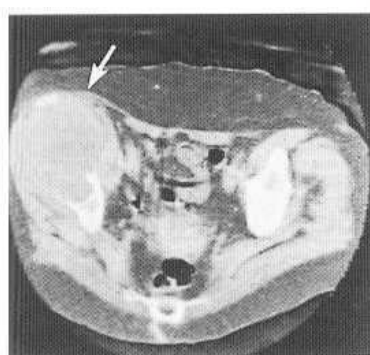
Metastasis from carcinoma of thyroid. (A) A localised view of the anterior inferior iliac crest shows a small radiolucent defect with a faint sclerotic margin (arrows). (B) Five years later a very large destructive bone lesion is present with relatively well defined margins and apparent strands of calcification within the lesion. (C) CT confirms the very extensive nature of the tumour and shows the soft-tissue planes to be preserved (arrow). The strands of calcification are shown to be residual bone anteriorly and posteriorly and not new bone in the metastasis. (D,E) Common iliac arteriography (subtraction images) demonstrates the very vascular nature of this metastasis. Note the increase in number of abnormal vessels with changing calibre, the dense tumour blush and early venous filling.
